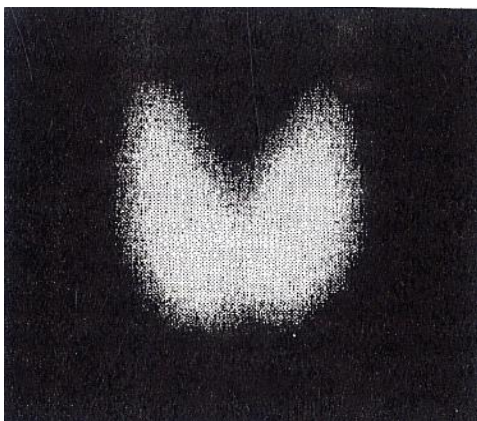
Graves' disease: thyroid scintigraphy
